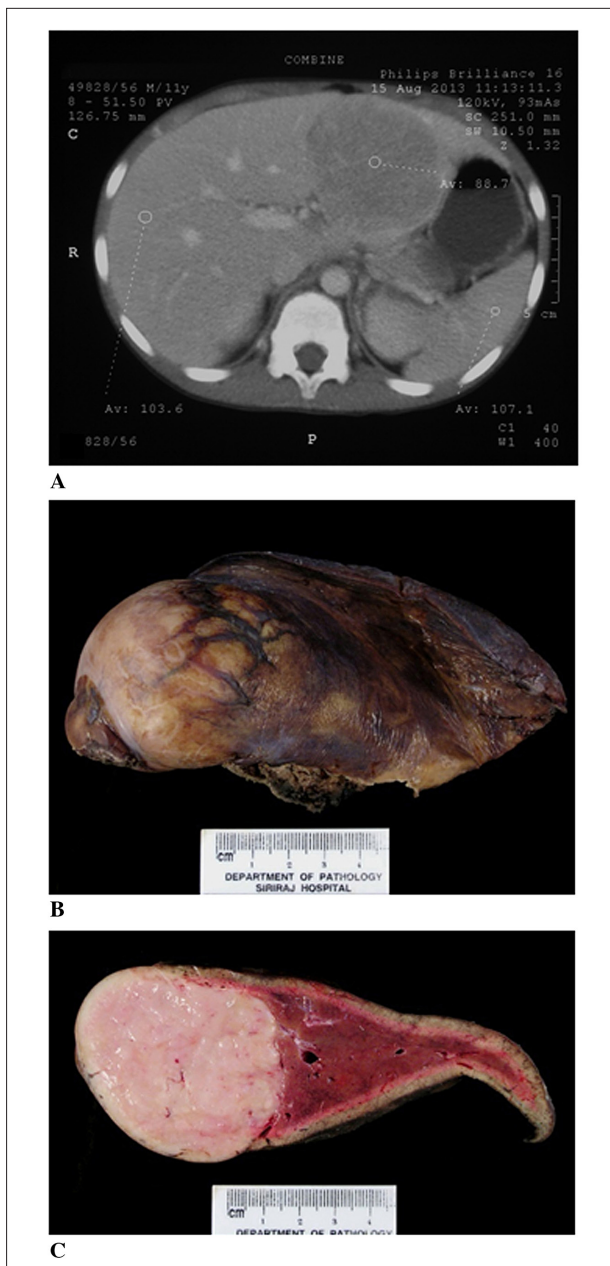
A) Computed tomography scan of the liver showing a hypodense mass. B&C) Tumor mass with normal remaining liver
